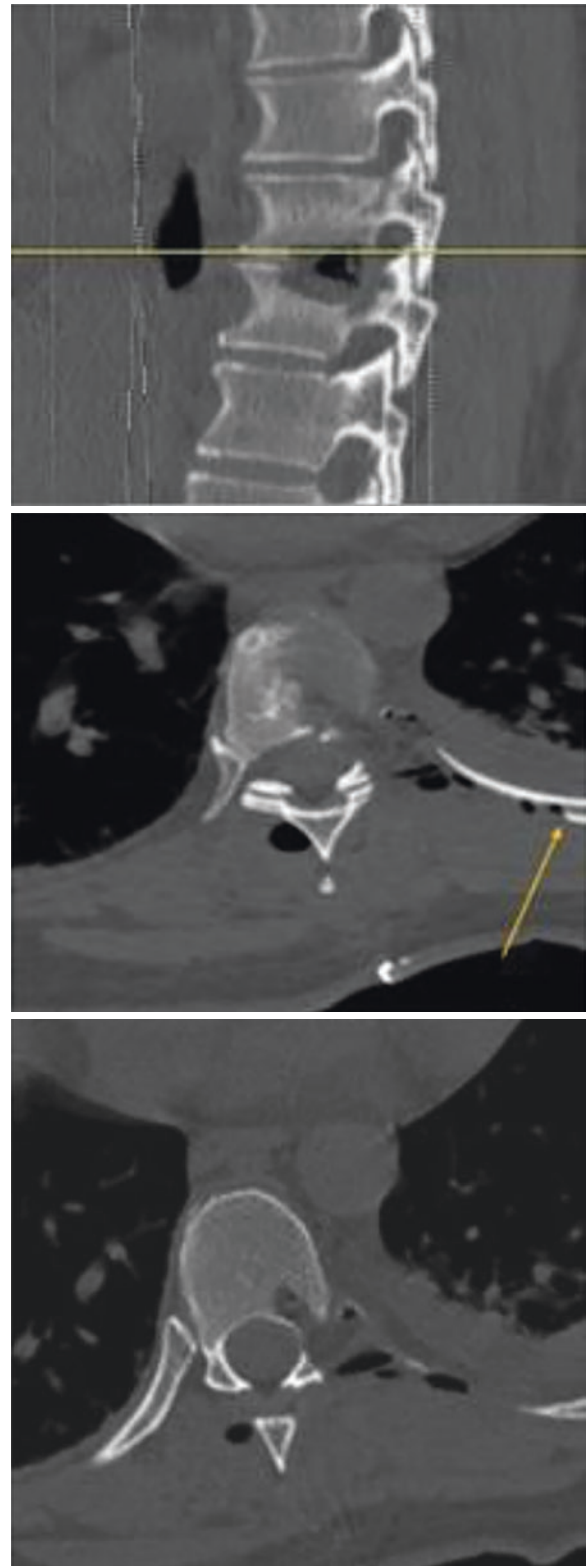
Postoperative CT scan: yellow arrow shows the flattened outer layer of the rib, via piezosurgery, which protects the pleura, while displacing down the rib provides an adequate and almost-tangential working angle to reach the medial part of the discal space
